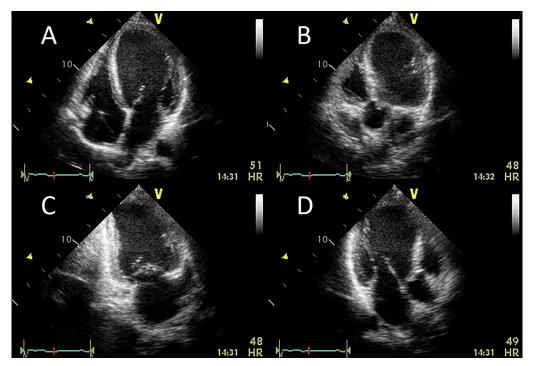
Final transthoracic echocardiogram performed 6 months after initial admission. Images are acquired from the apical windows and represent apical four-chamber (A), apical five-chamber (B), apical two-chamber (C), and apical long-axis (D) views. These show further remodeling of the left ventricle, with thinning and scarring of the apical segments. No obvious LV apical thrombus is seen.
